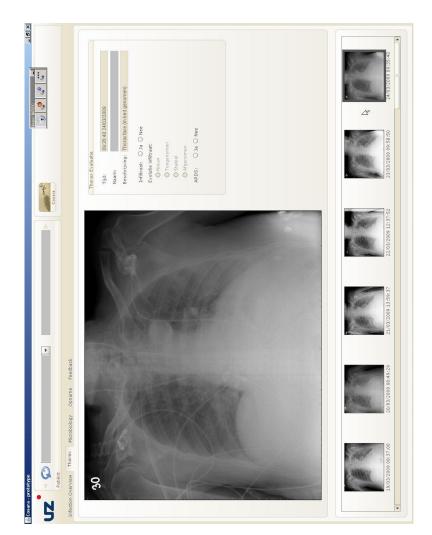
The client shows a history of chest X-ray images and an evaluation form. The form on the right is used to calculate the Clinical Pulmonary Infection Score (CPIS) based on occurence of infiltrate (and its evolution), indication of acute respiratory distress syndrome (ARDS) and other laboratory values.
